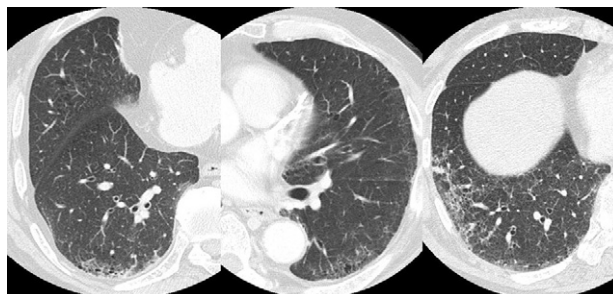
Preoperative high-resolution computed tomographic films of computed tomographic honeycombing in three patients. Focal, not diffuse subpleural dorsal honeycombing with focal fibrotic changes can be seen.
